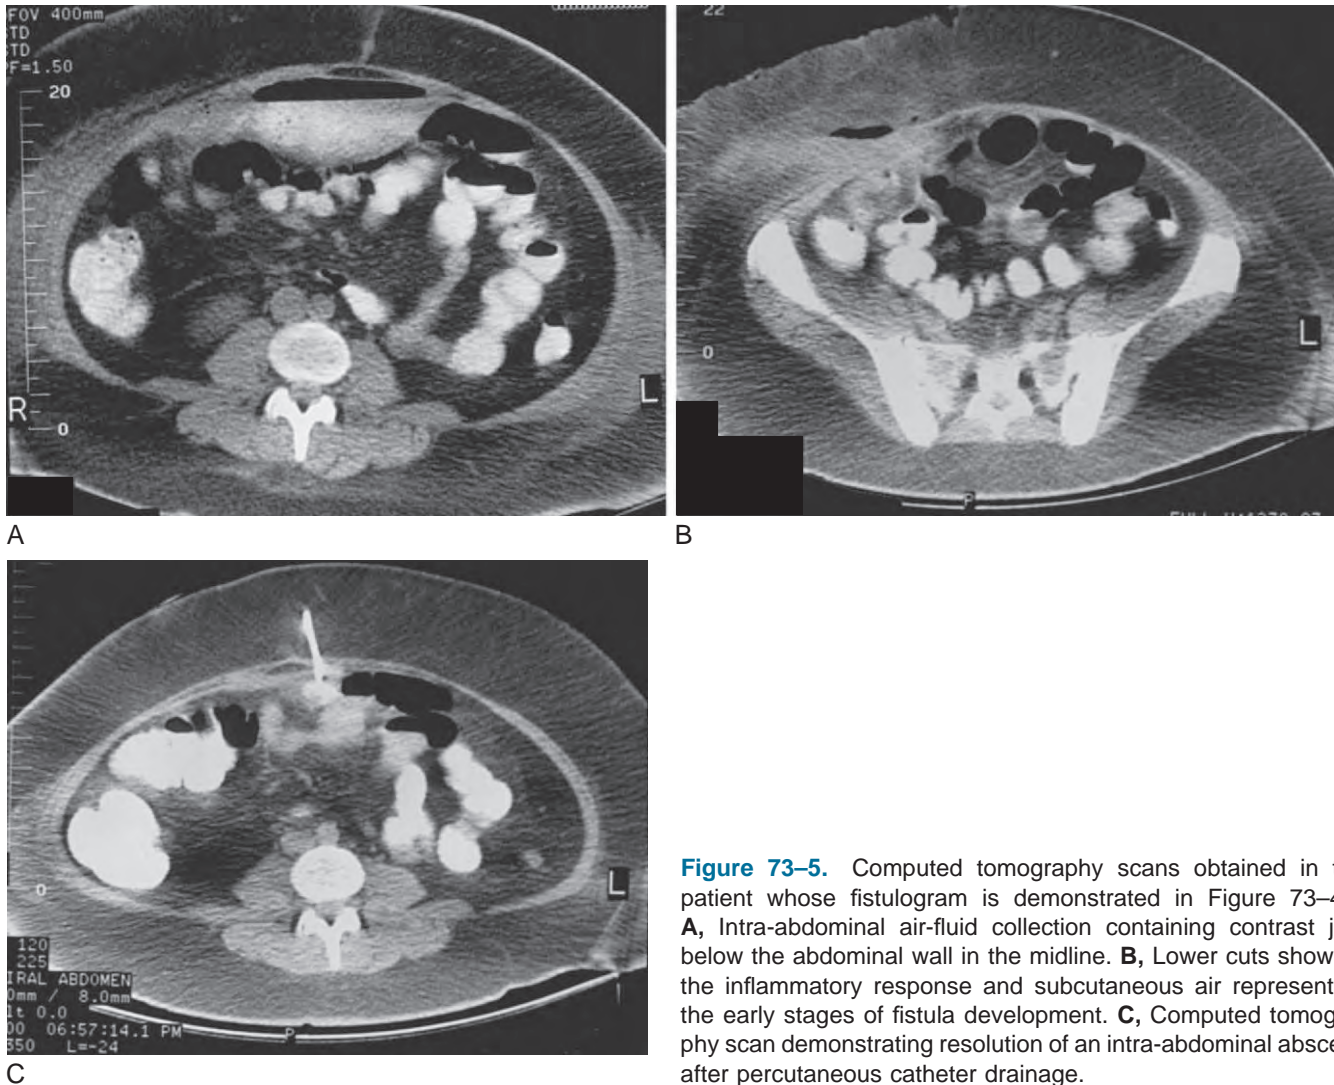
Computed tomography scans obtained in the patient whose fistulogram is demonstrated in Figure 73-4B. A, Intra-abdominal air-fluid collection containing contrast just below the abdominal wall in the midline. B, Lower cuts showing the inflammatory response and subcutaneous air representing the early stages of fistula development. C, Computed tomography scan demonstrating resolution of an intra-abdominal abscess after percutaneous catheter drainage.
